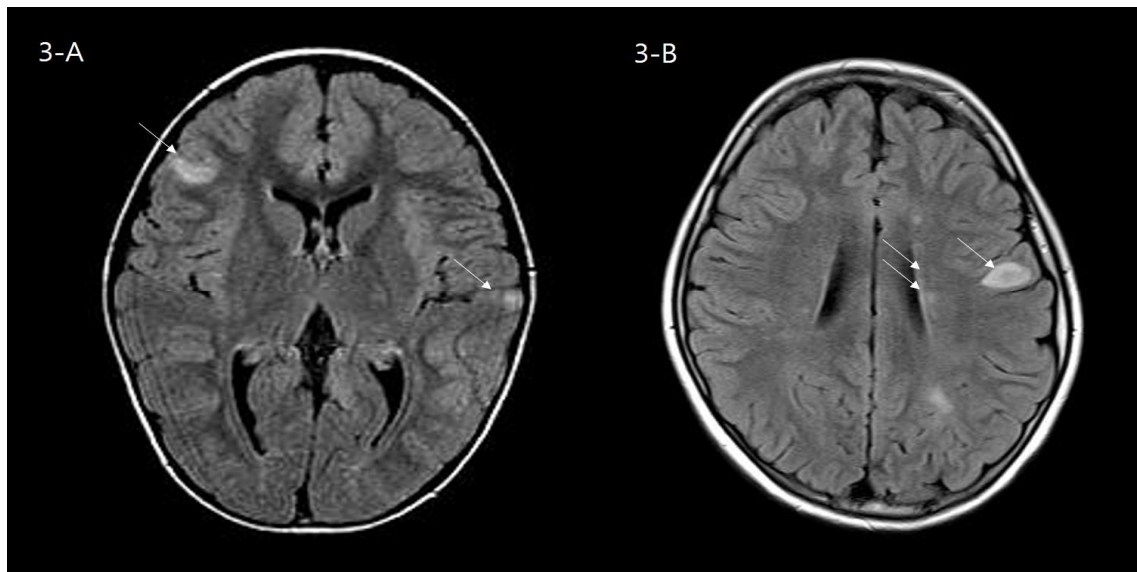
Brain MRI of patient 35 diagnosed with MS (MOG antibodies positive). Juxtacortical or subcortical lesions including cortex are shown on The T2 FLAIR (A). Periventricular and subcortical lesions are shown on The T2 FLAIR (B). MRI, magnetic resonance imaging; MOG, myelin oligodendrocyte glycoprotein; FLAIR, fluid-attenuated inversion recovery
